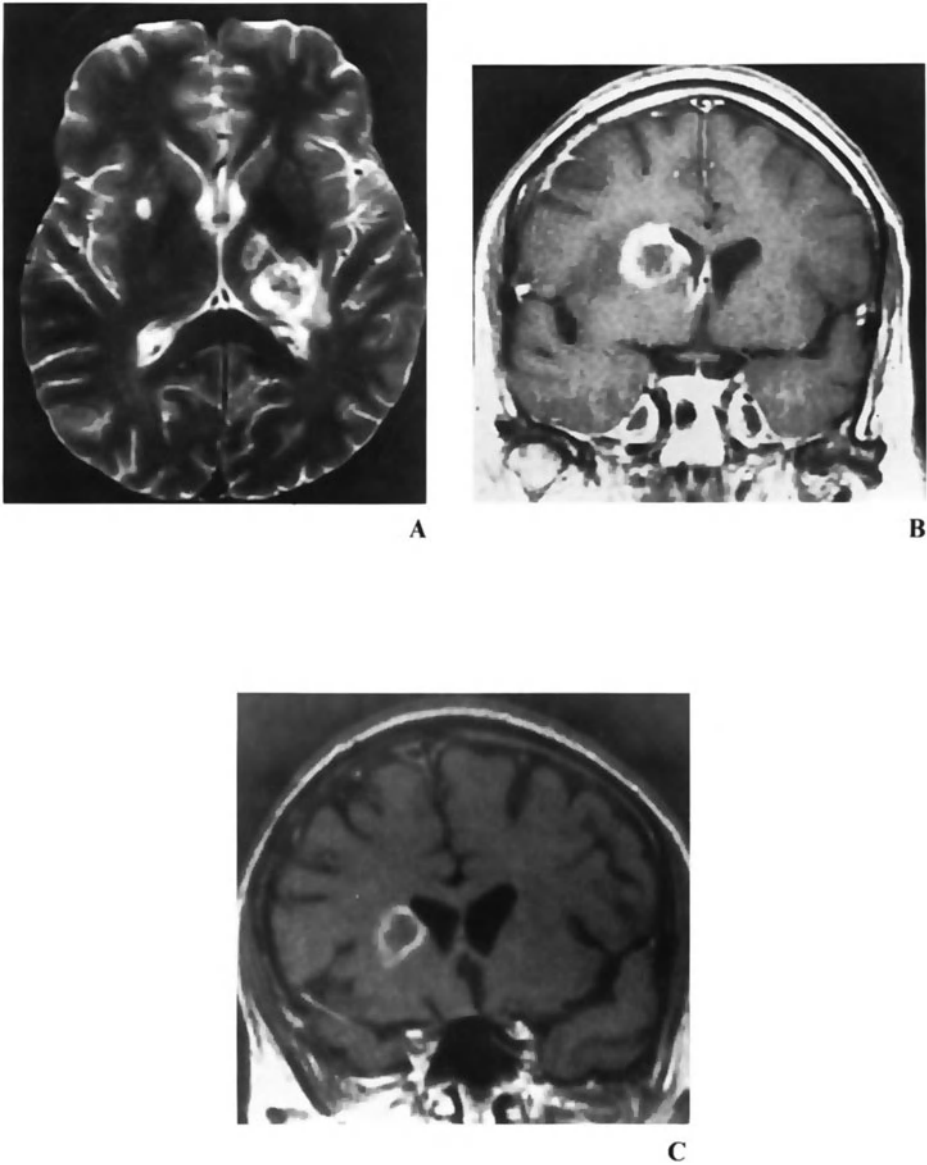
Toxoplasmosis. (A) Axial  $T_2$ -weighted MR image in a 46-year-old gay man with AIDS shows high-signal lesions in the right putamen and left thalamus, common sites for *Toxoplasma* infection (TR = 2800, TE = 80). (B) Coronal  $T_1$ -weighted gadolinium-enhanced MR image from another AIDS patient shows a solitary ring-enhancing lesion in the right periventricular white matter (TR = 600, TE = 20). (C) The same lesion after 2 weeks of empirical anti-*Toxoplasma* therapy shows decreases in the size of the lesion, surrounding edema, and mass effect (TR = 500, TE = 30)
